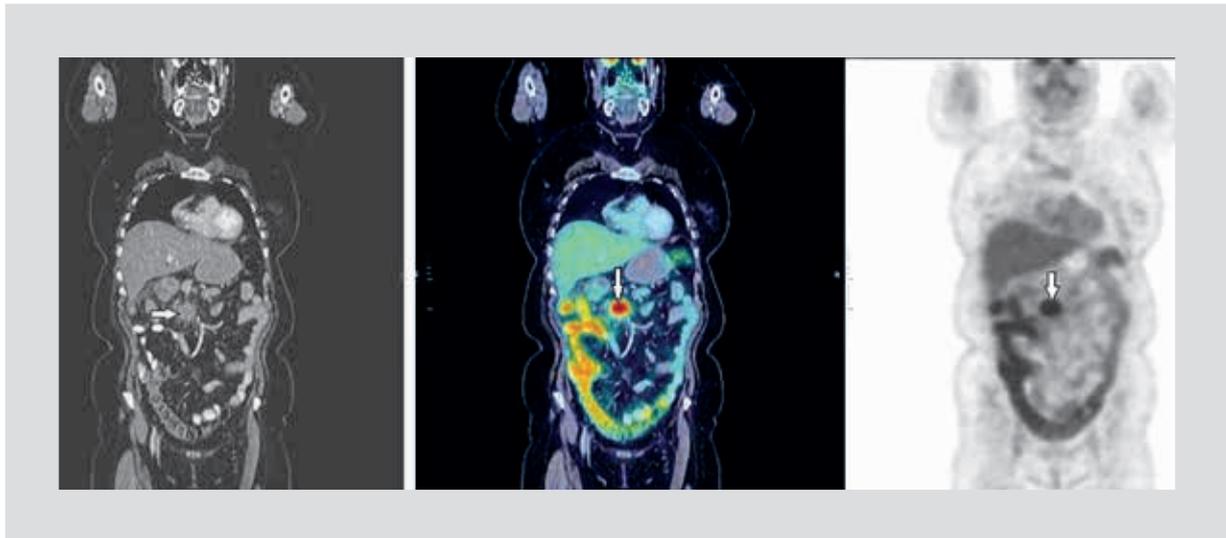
62-year old women diagnosed with moderately differentiated adenocarcinoma of the ascending colon, clinical stage IVA, managed with surgery and chemotherapy. CEA of 18.4 ng/ml. The PET/CT scan with ^{18}F FDG shows a hypermetabolic lesion in the mesentery, with a SUV_{max} of 11 (white arrows).
